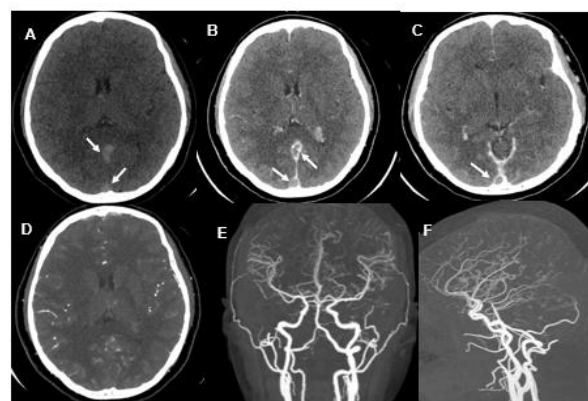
Brain computed tomography angiography (CTA) conducted upon the patient's admission, approximately seven days following the onset of headaches. In the axial section without contrast agent (A), a spontaneous hyper density is identified within the right sinus and the superior longitudinal sinus, indicative of the "dense triangle" sign, which suggests the presence of a thrombus. Following the administration of the contrast agent (B and C), enhancement of the sinus wall is noted, outlining a central hypo density in the right sinus and the superior sagittal sinus, corresponding to the "Empty delta" sign. No abnormalities are detected during the arterial examination (D, E, and F).
